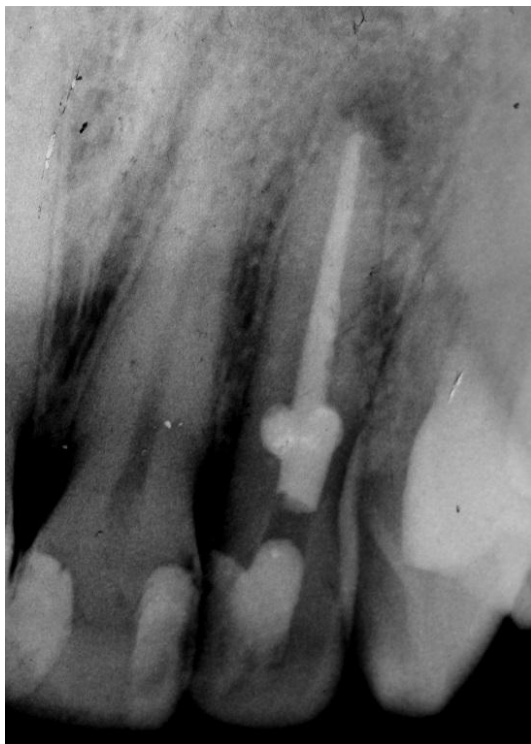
Final distal radiograph
